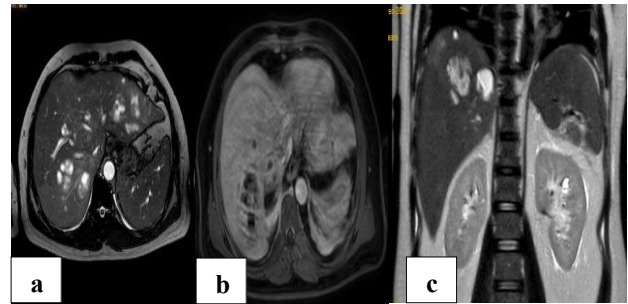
(a-c): Abdominal MRI with contrast image result of the patient showing multiple cystic lesions, acalculous cholecystitis, and small cyst in upper pole of left kidney.
